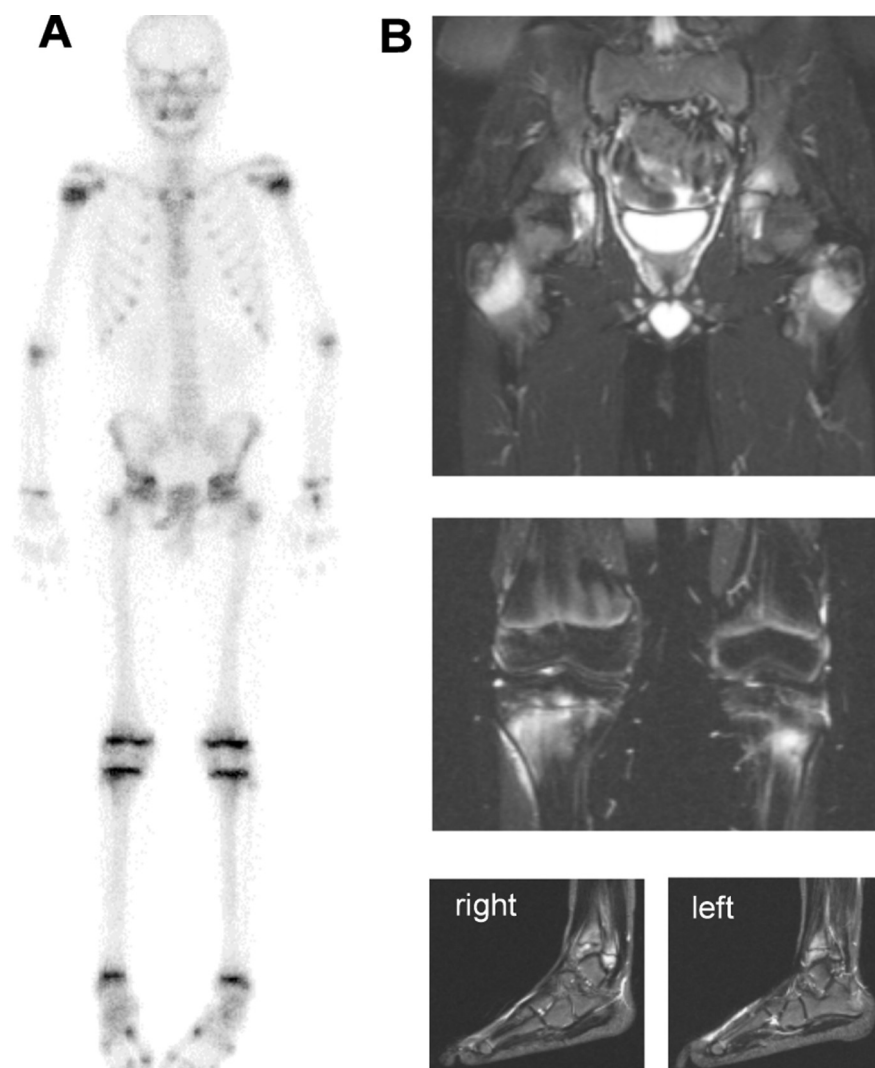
99m Technetium-labelled methylene diphosphonate (Tc-99m MDP, A) and TIRM sequences of magnetic resonance imaging (MRI, B) in an 11-year old boy with biopsy proven chronic non-bacterial osteomyelitis (CNO). Bone scintigraphy shows physiological tracer uptake in the metaphyseal regions of the pelvis, proximal and distal femur as well as proximal and distal tibia. MRI shows a symmetrical increased T2-TIRM signal in both sides of the pelvis, proximal and distal femur as well as in the proximal and distal tibia indicative for inflammatory lesion.
